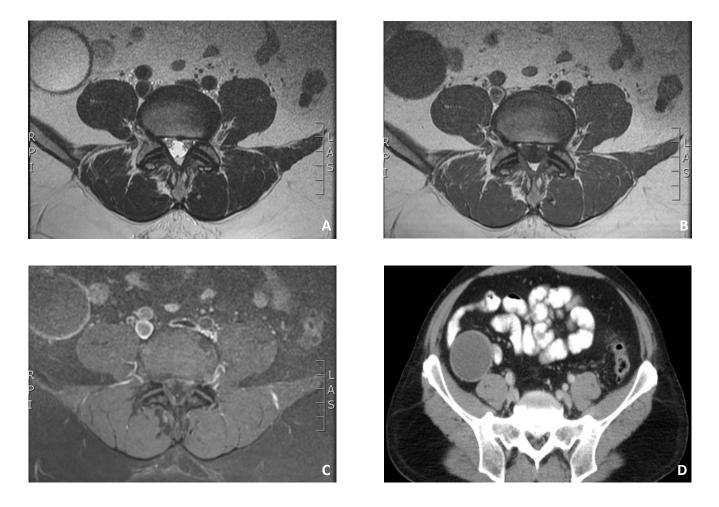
Axial T2 (A), axial T1 (B), and post contrast fat saturated axial T1 (C) images through the level of the cecum demonstrate a fluid signal lesion within the right lower quadrant with thin wall enhancement. Axial post contrast CT image at the same level (D) reveals similar findings, as well as a lack of conspicuous mural calcifications or surrounding inflammatory changes.
